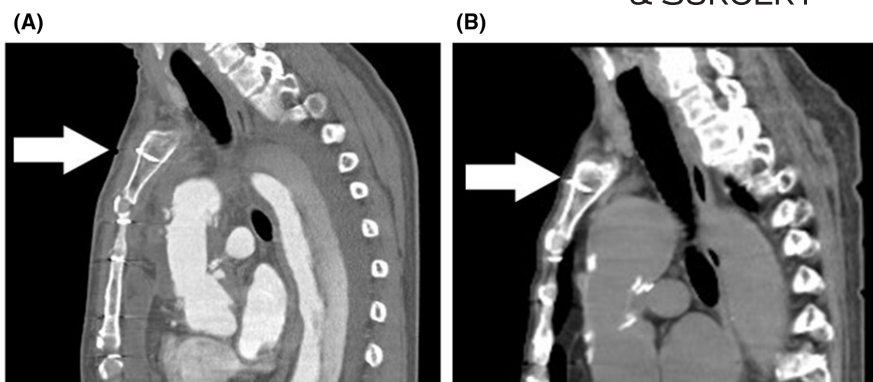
(A, B) Computed tomography scans taken 1 year before the collapse day (11 years after surgery). The thickness of the tissue under the chest skin decreased (arrow).
